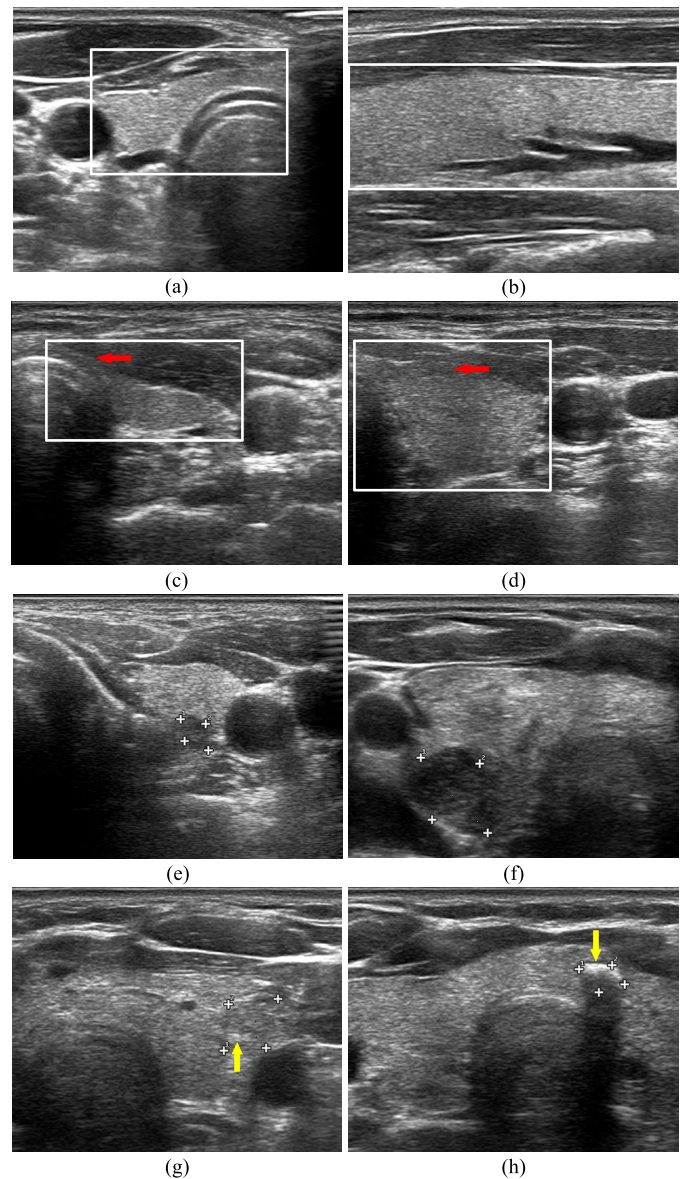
Ultrasound images with thyroid glands and thyroid nodules. (a) ~ (d) are thyroid ultrasound images of thyroid glands with different shapes and sizes from different views, and the white rectangular frames indicate the thyroid gland regions. (e) ~ (h) are thyroid ultrasound images with various thyroid nodules with four white markers indicating the thyroid nodule regions. (b) is from longitudinal view and the others are from transverse view.
